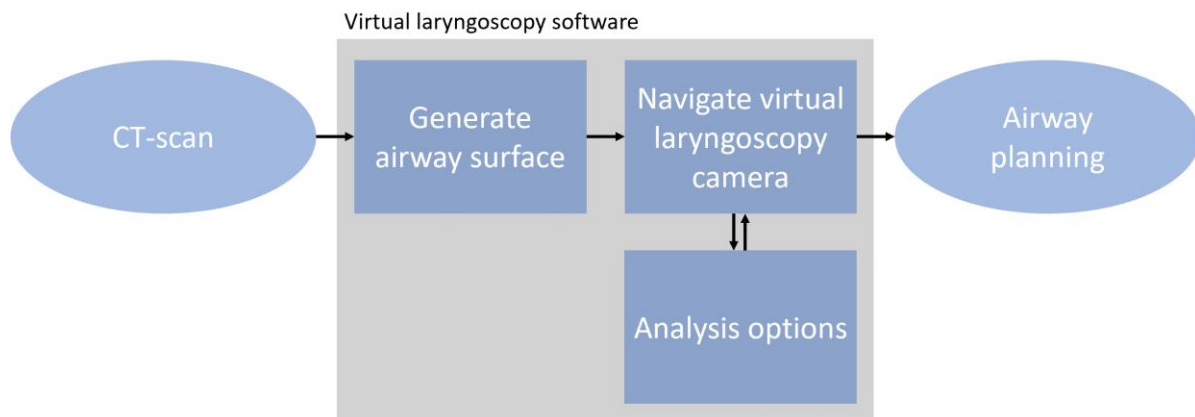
Overview of the created VL wizard. A CT-scan is loaded into the software, where the airway surface is generated. The user is able to view the intraluminal airway surface by navigating the VL camera. Simple analysis options are added to enable better airway examination. The software is designed to support the anesthesiologists in difficult airway planning.
